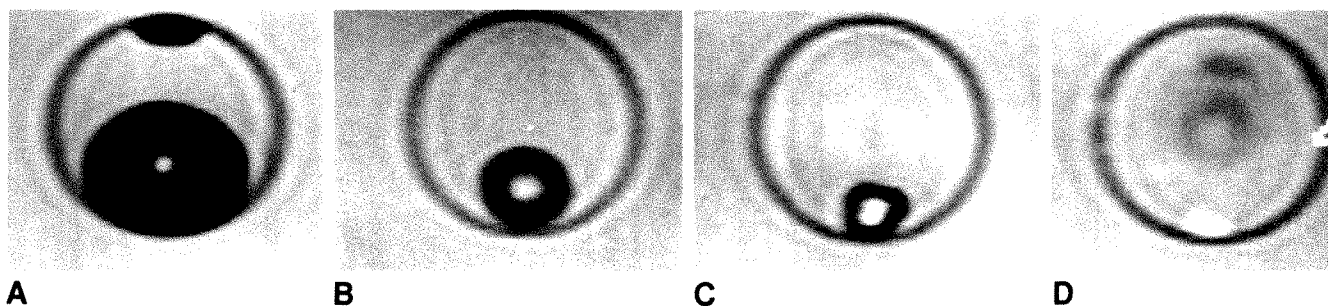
Size (area) of increased gallstone signal intensity on T1-weighted MR images was estimated by comparing diameter of area of visible increased MR signal with entire gallstone diameter. An area of increased signal <25% was considered small (A); areas of 25–50% were considered medium (B) and 51–99%, large (C). When area of increased MR signal occupied entire gallstone without areas of signal void, area was considered total (D).
